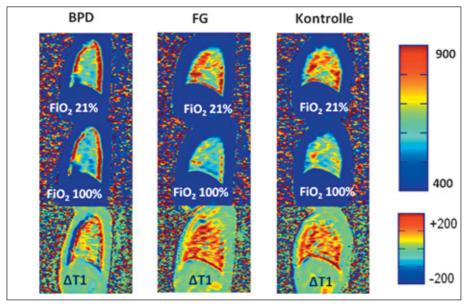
Colour-coded images of pulmonary T1-relaxation times (MRI, 0.2 Tesla) from 3 children at school age, a former preterm neonate with bronchopulmonary dysplasia (BPD), a former preterm neonate without BPD (FG), and a healthy child born at term (Kontrolle). Upper panel: Values obtained when breathing room air. Middle panels: Values with pure oxygen. Lower panel: Differences in the T1-relaxation times (Δ T1) are lower in the child with former BPD than in the other children indicating impaired regional pulmonary function. (Images provided by Prof. Dr. M. Beer).
